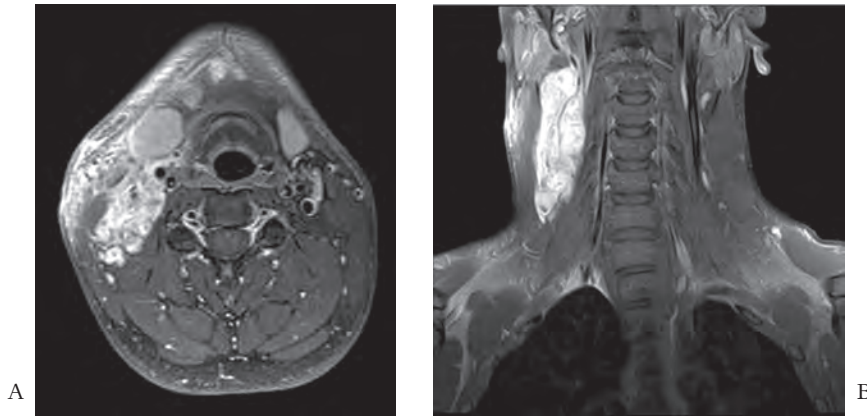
Axial (A) and coronal (B) T1-weighted, gadobutrol-enhanced magnetic resonance images showing an enhancing mass, which invades internal and external carotid arteries anterolaterally; the internal jugular vein was invisible
